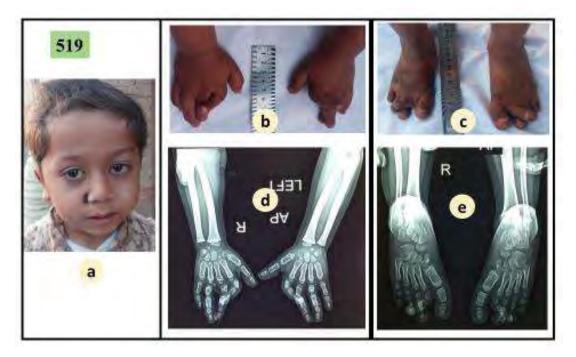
Morphological and radiographic features in patient 519. Broad forehead and large ears (a), short, abducted thumb and over lapping fingers (b), halluces with varus inclination in feet (c), hypoplastic distal phalanges with extraosseous elements in hands and feet (d, e).
